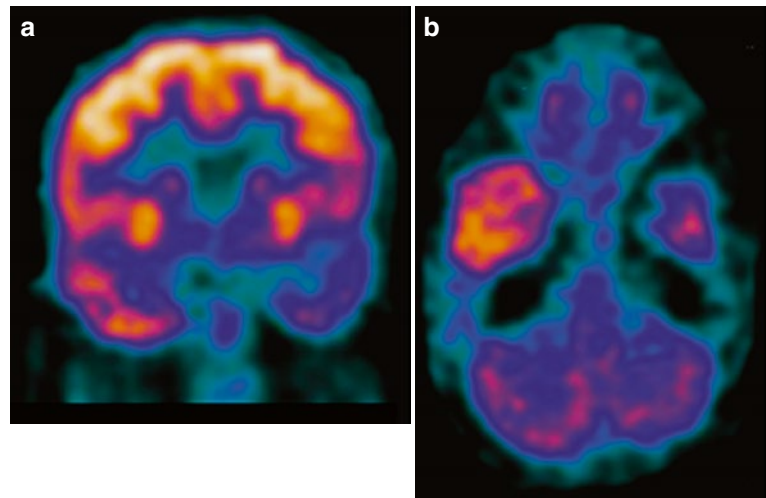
Interictal ^{18}F -FDG PET in a patient with intractable seizures. There is less tracer uptake in the left temporal lobe
